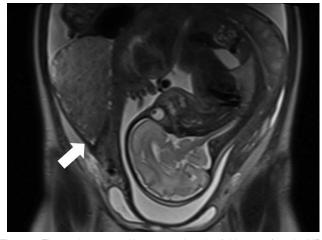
The ovarian tumor with suspected torsion (white arrow) on the MRI.
